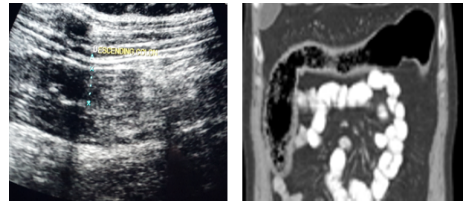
USG and CT images shows diffuse wall thickening of colon and shows homogenous enhancement in CT images.
